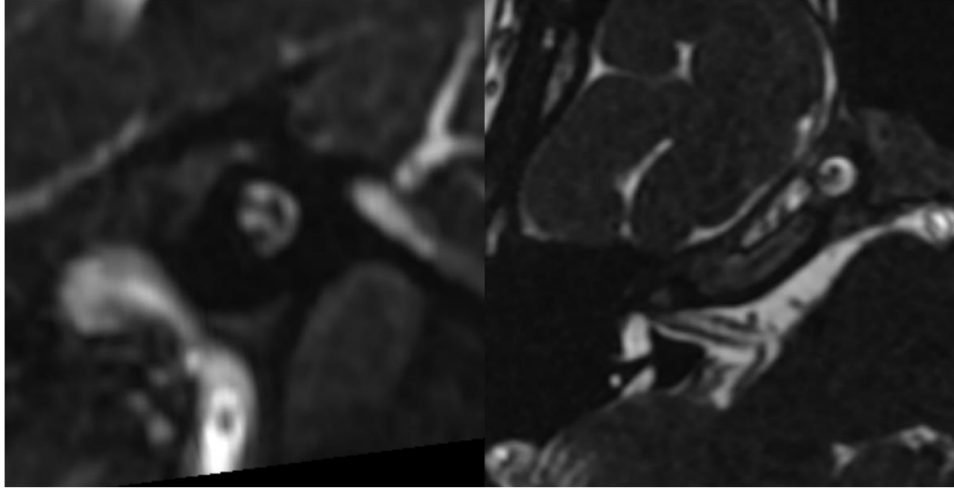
High-resolution T2-weighted MRI demonstrating preservation of the right cochlear nerve
